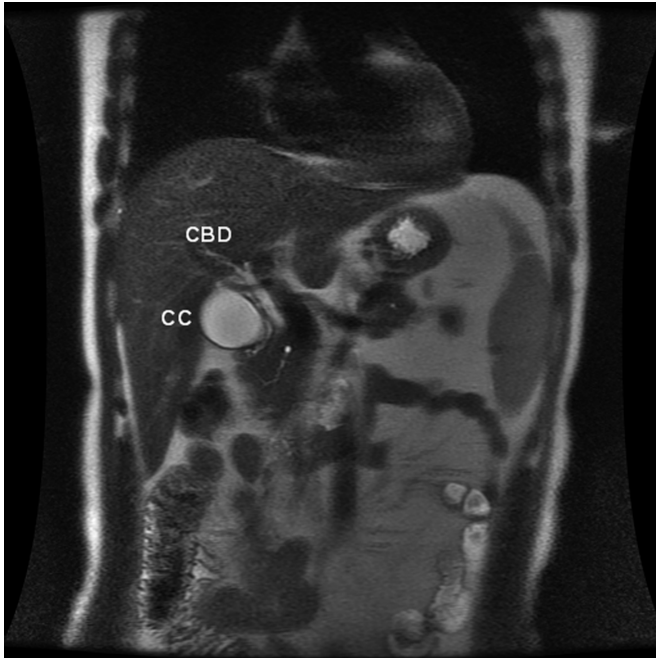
MRI (GB=gallbladder, CBD=common bile duct).
